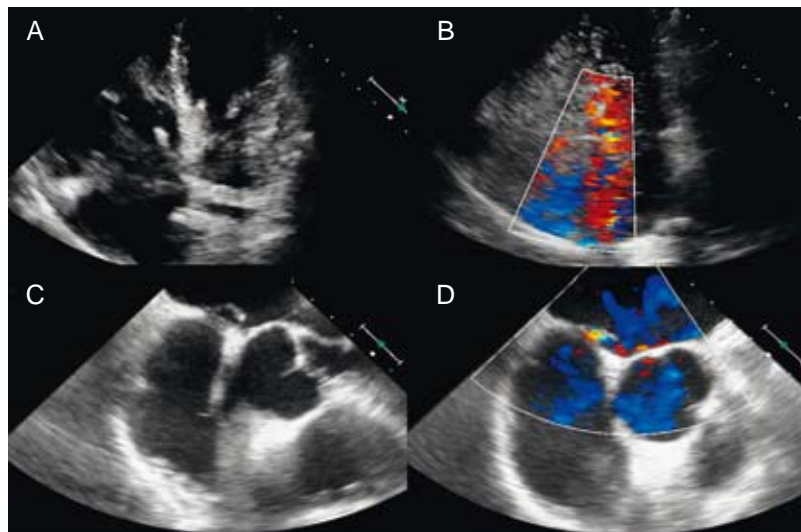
A and B) Transthoracic echocardiogram. C and D) Transesophageal echocardiogram.
